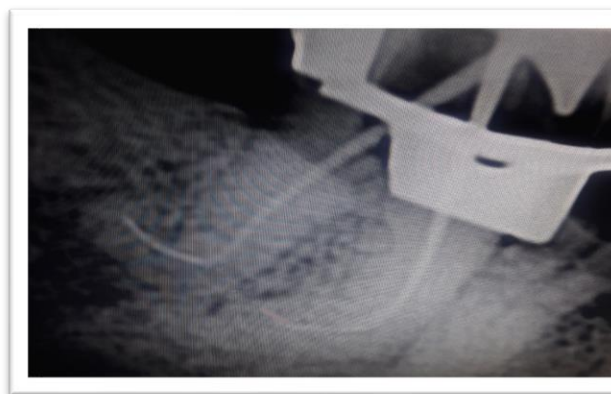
C: Master cone radiograph.
